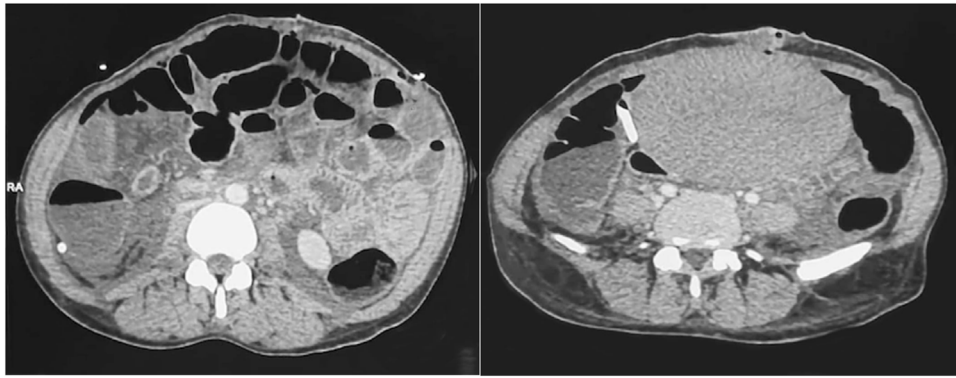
CT-scan of the abdomen showing intraperitoneal free fluid with paralytic ileus but without any sign of arterial or venous thrombosis.
